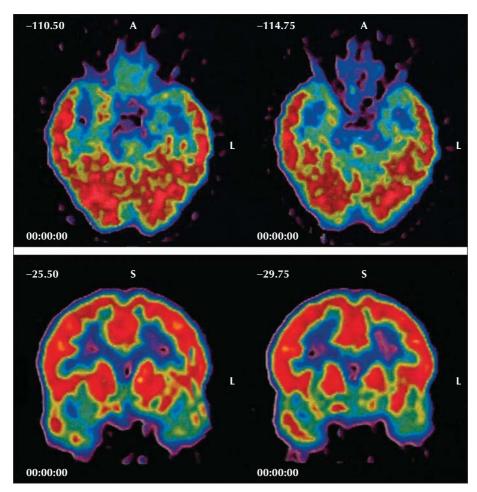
Transverse and coronal ¹⁸F-FDG-positron-emission-tomography sections, showing a left temporal hypometabolism.
